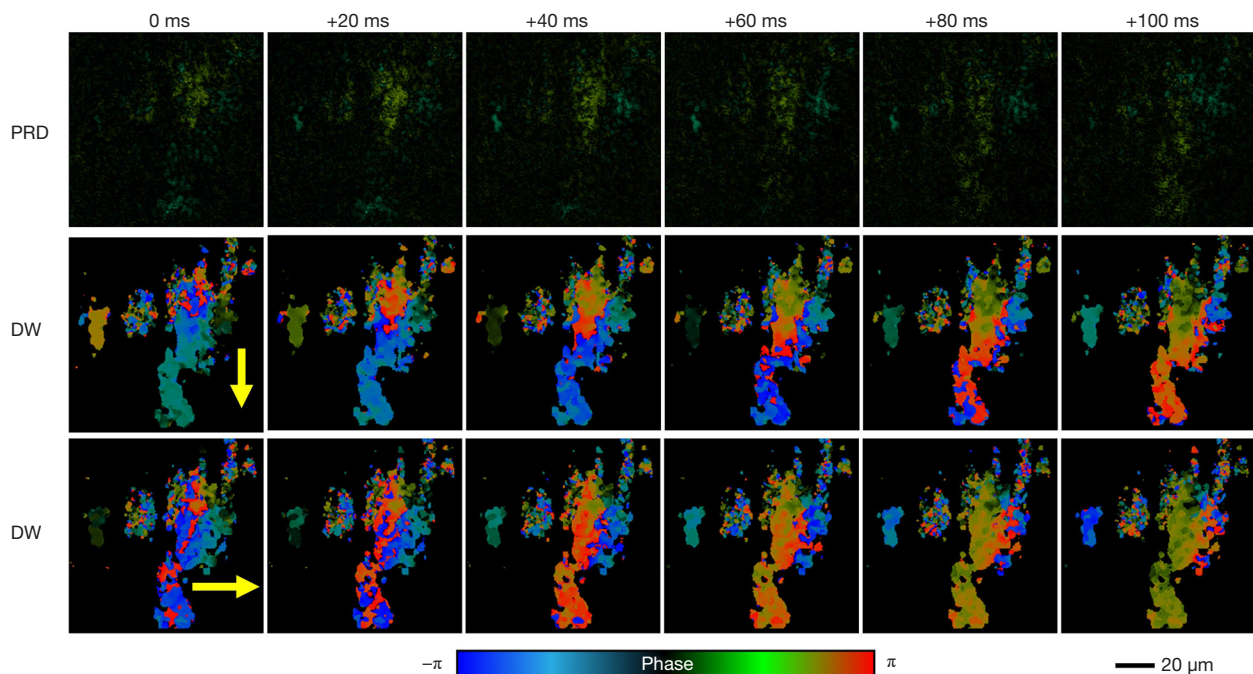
Visualization of dynamic wavefront and metachronal wave propagation at ROI 1. Yellow arrows in the dynamic wavefront images indicate the direction of metachronal wave propagation. Metachronal waves can hardly be resolved in the time-series phase-resolved Doppler images. See Video S1. PRD, phase-resolved Doppler; DW, dynamic wavefront; ROI, region-of-interest.
